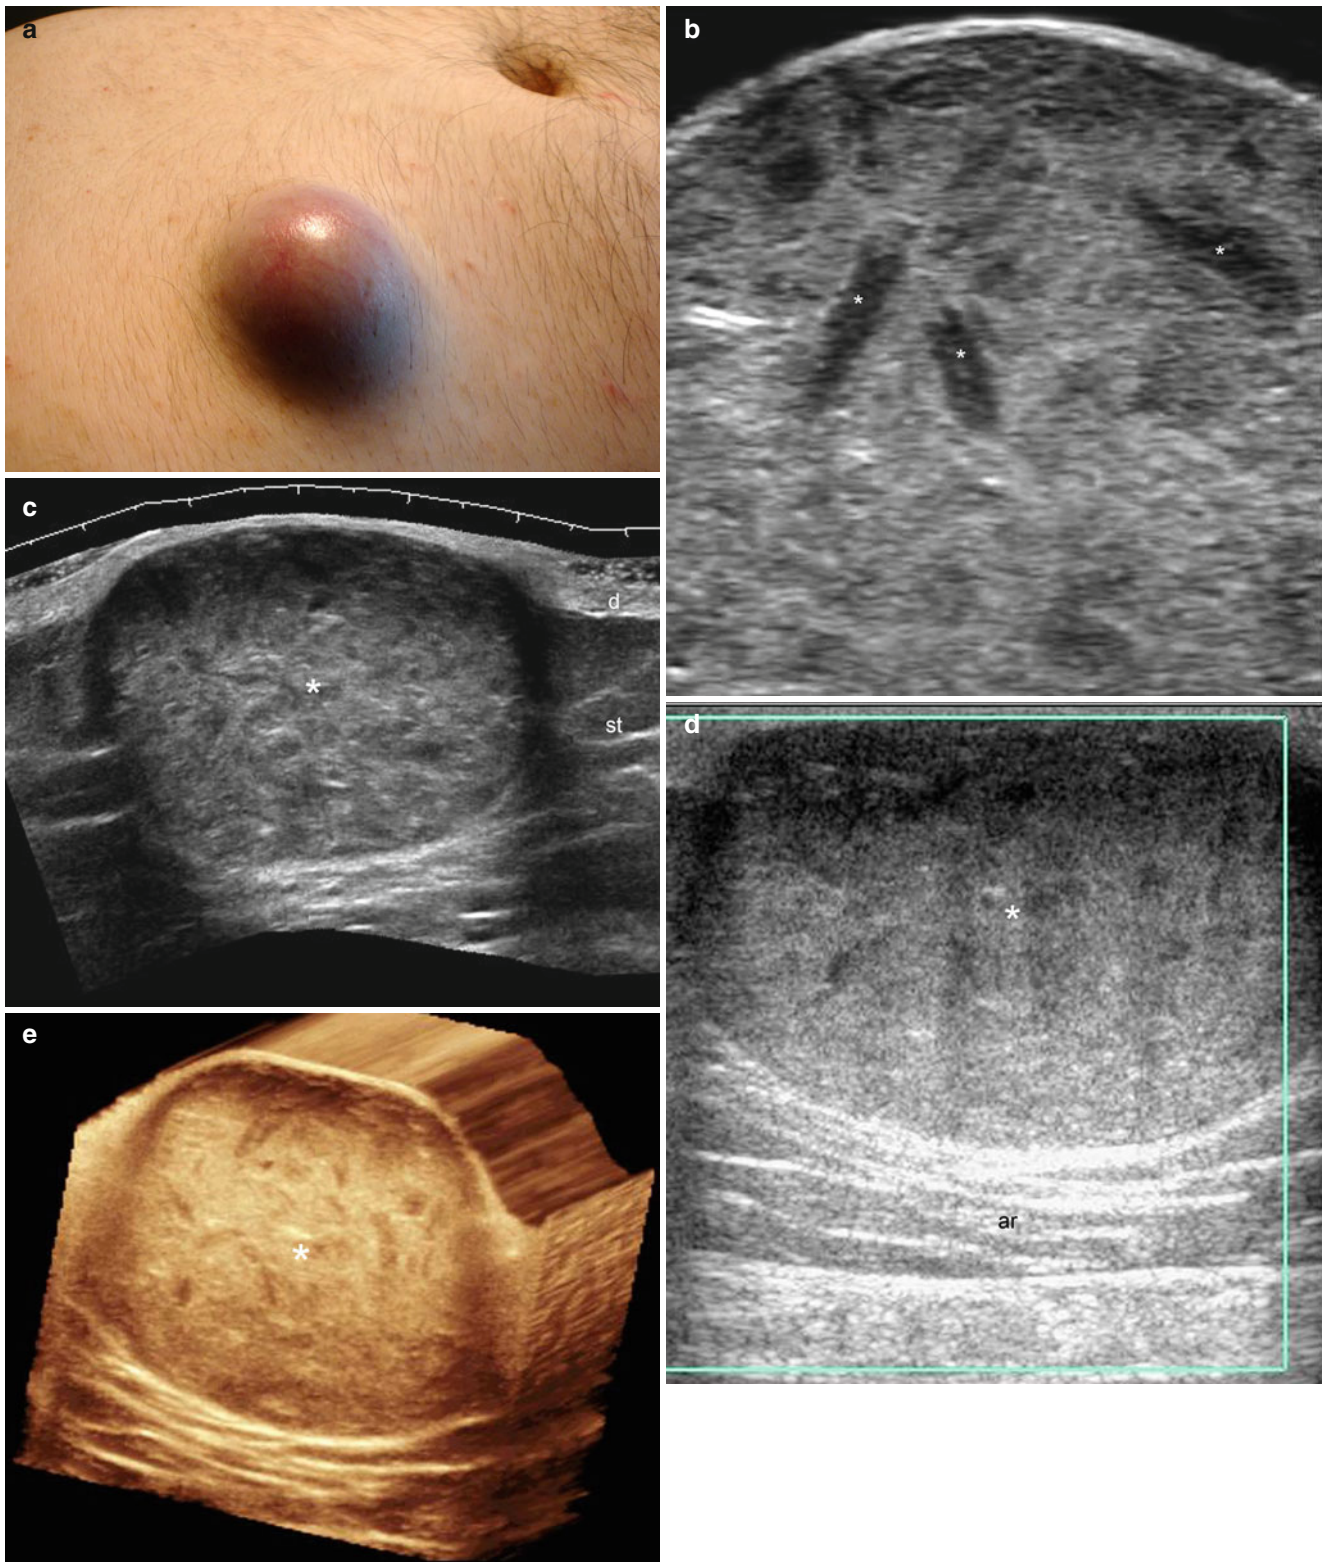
(a–e) Epidermal cyst with “pseudotestes” appearance. (a) Clinical lesion shows an erythematous swelling in the right aspect of the abdominal wall. (b) Grey scale ultrasound image (transverse view) demonstrates the upper part of the cyst in the dermis and subcutaneous tissue. There is echogenic material that corresponds to compact keratin and some hypoechoic bands (*) that represent cholesterol deposits. (c) Grey scale ultrasound image (extended transverse field of view) of the cyst
